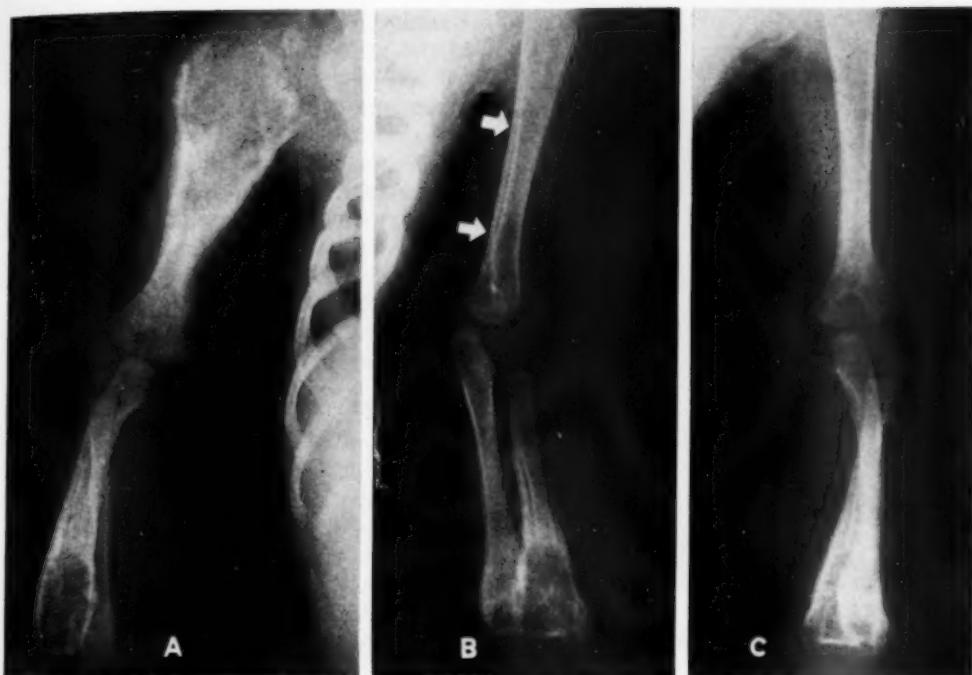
Unique destructive and proliferative lesions involving right humerus, right radius, right ulna, left radius, and left ulna. Similar lesions were found in both femurs, the left tibia and fibula, and the left seventh rib. Roentgenologic diagnosis was malignant neoplasm of indeterminate type. Pathologic diagnosis based upon biopsy and extensive necropsy was malignant hemangioblastoma.
